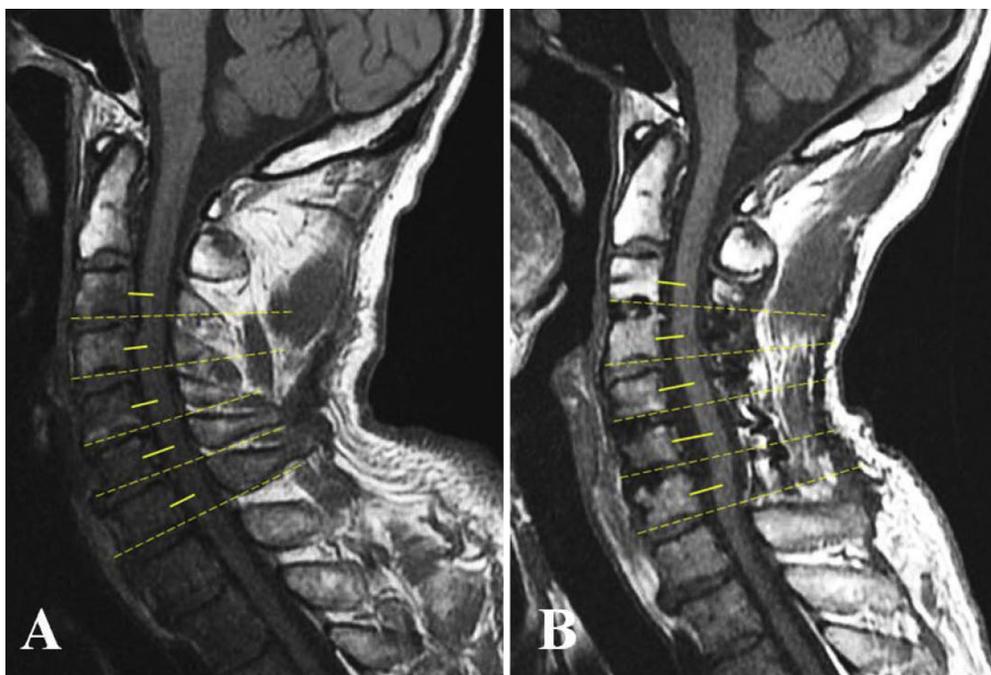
The distance from posterior edge of vertebral body to the center of spinal cord at each decompressed cervical level was measured using T1-weighted images preoperatively (A) and postoperatively (B).
